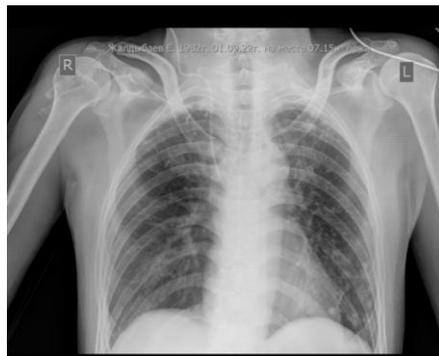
Chest X-ray 01.09.2022 Pneumosclerosis of the lungs, post-tuberculosis changes in the left and right lungs
